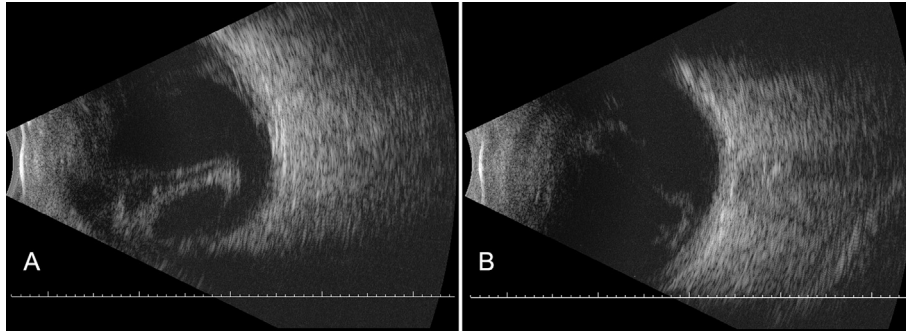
B-scan ultrasound showing posteriorly dislocated lens (a) with sheets of vitritis (b) consistent with endophthalmitis.
